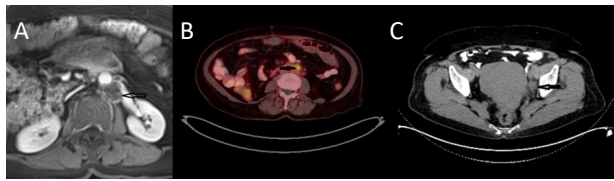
Imaging modalities through (A) MRI, (B) PET, (C) CT. Images obtained using magnetic resonance imaging (MRI), positron-emission tomography (PET), and computed tomography (CT), respectively, demonstrate the anatomical and functional characteristics of the lesion.
